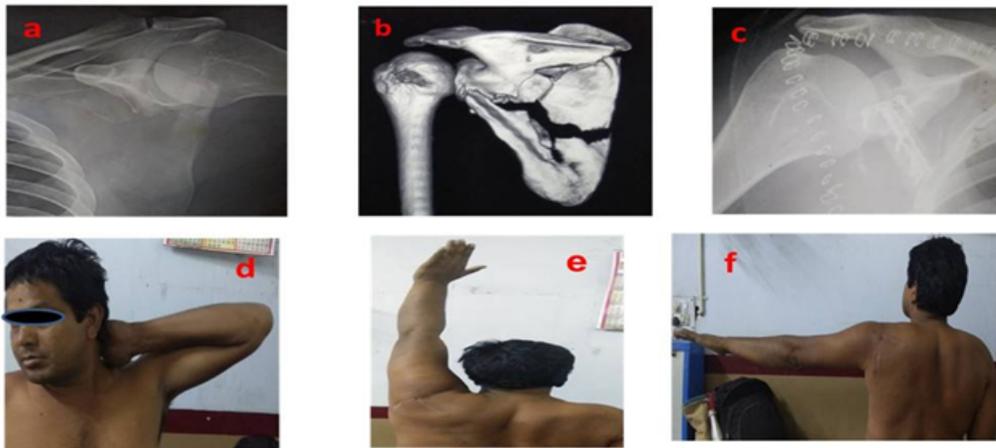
(a,b) X-ray and CT of a 47 years male with AO type F0/OTA 14 C1 type fracture. (c) post-operative x-ray. (d,e,f) 2nd year f/u clinical images.
